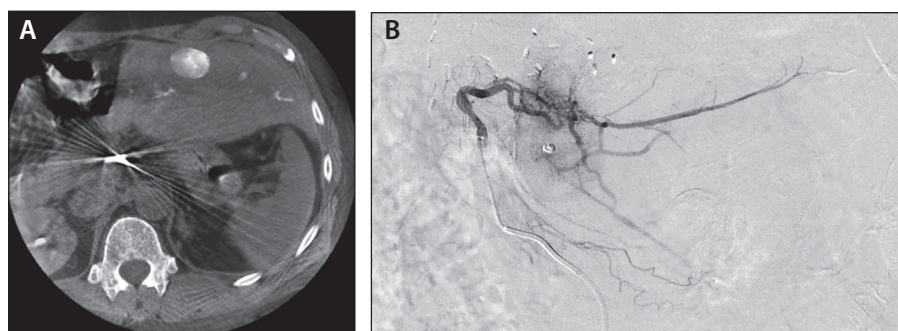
After administration of 100–300-µm doxorubicin-eluting microspheres at both sites, the final arteriogram showed resolution of tumor blushes and retained patency of the collateral network, segment 2 artery, and proximal segment 3 artery (A). Unenhanced cone-beam CT showed retention of iodinated contrast medium in the tumors, as well as in some peripheral arteries (B).
